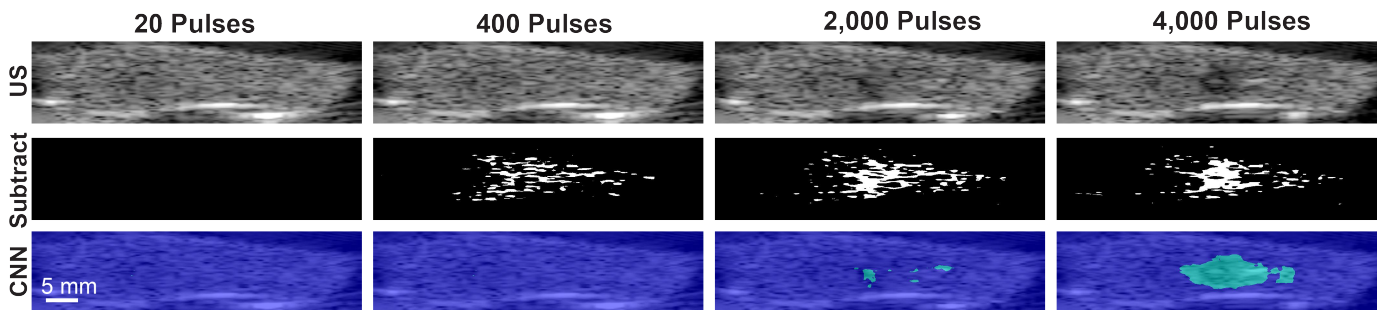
(Top Row) Ultrasound images of kidney being exposed to histotripsy. Outcomes for subtraction imaging (Middle Row), and the CNN (Bottom Row) are also shown. The number of applied pulses are identified for each column at the top of the image.
